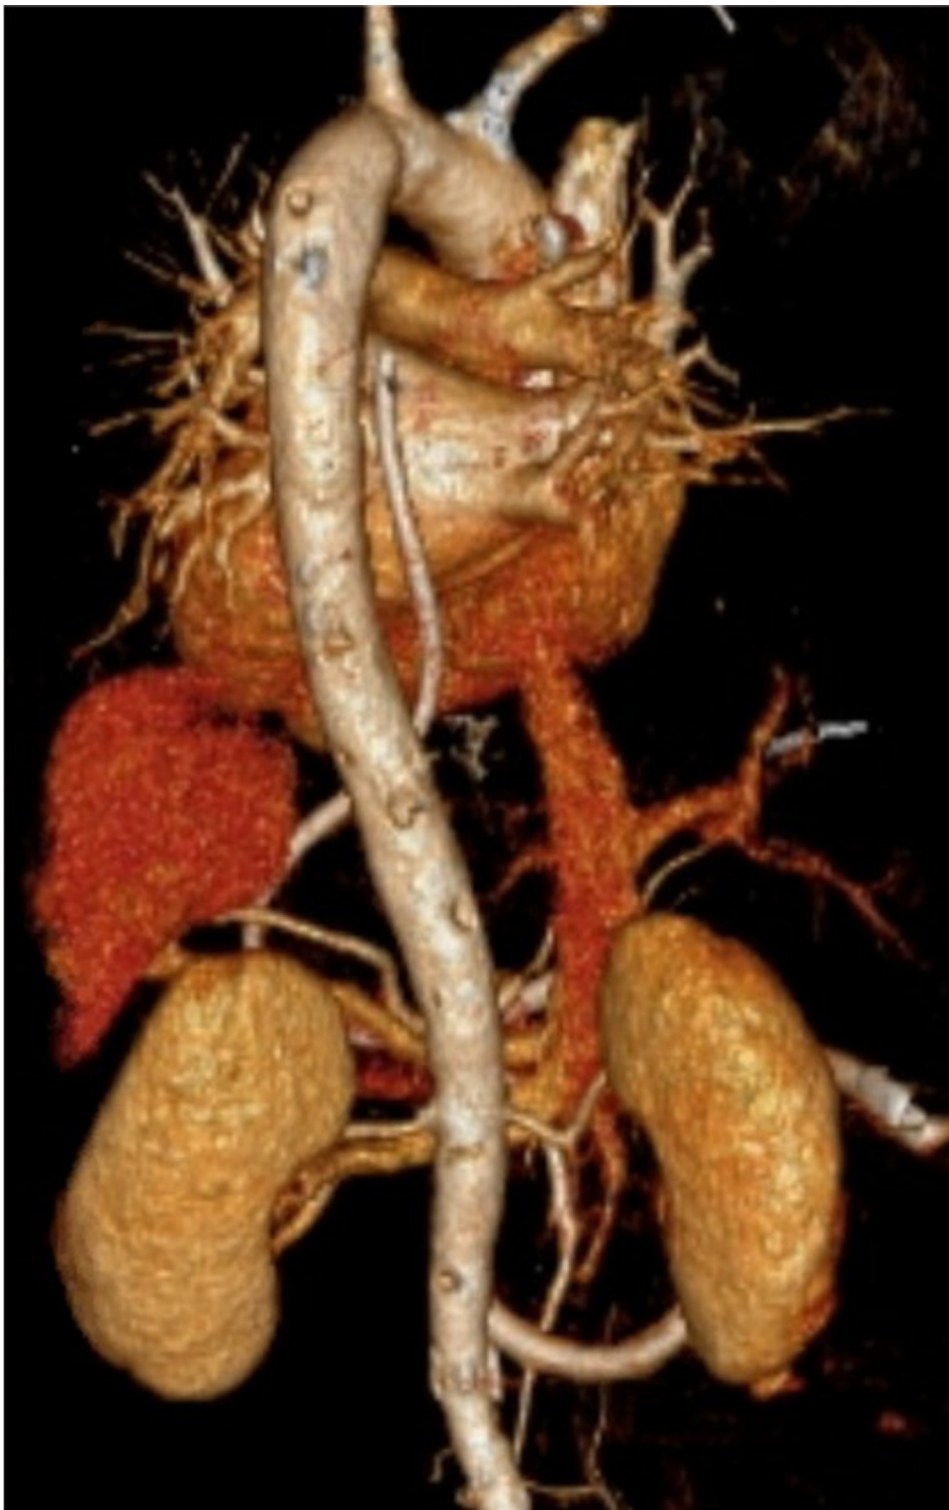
Computed tomography angiography with three-dimensional vascular reconstruction demonstrating multiple aortic thrombi in the ascending aorta, proximal arch, descending aorta, and infrarenal aorta.
